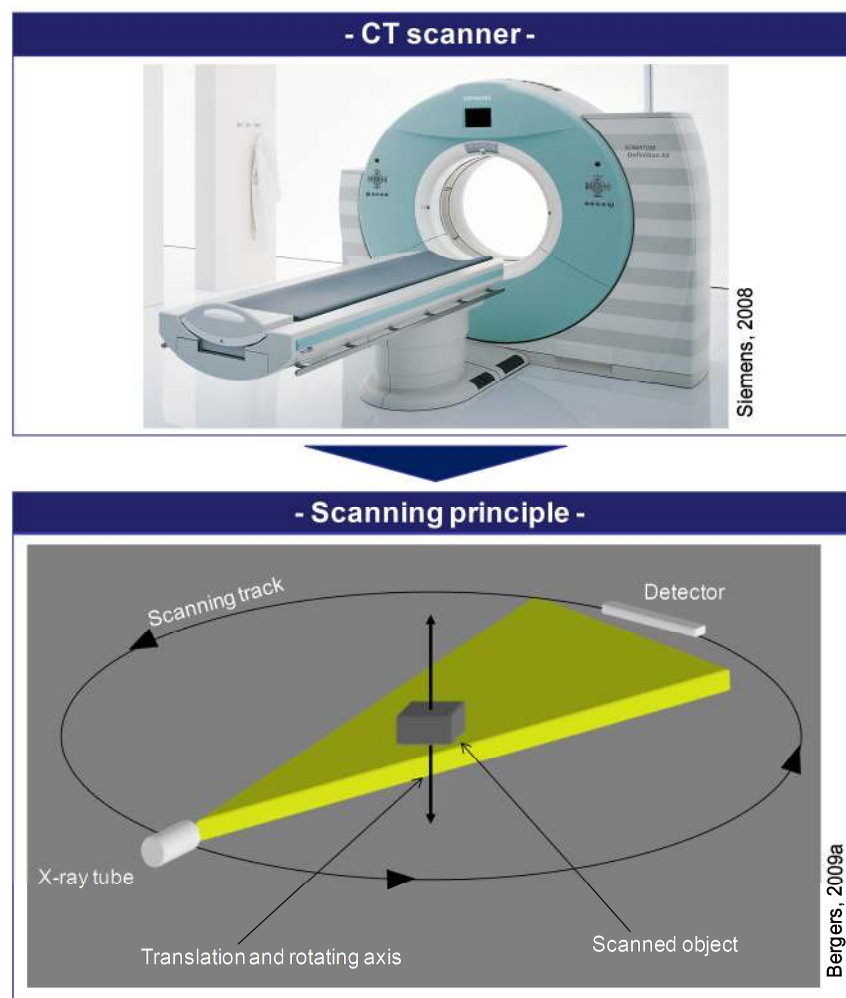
CT Scan process (adapted from Siemens, 2008; Bergers, 2009a)
